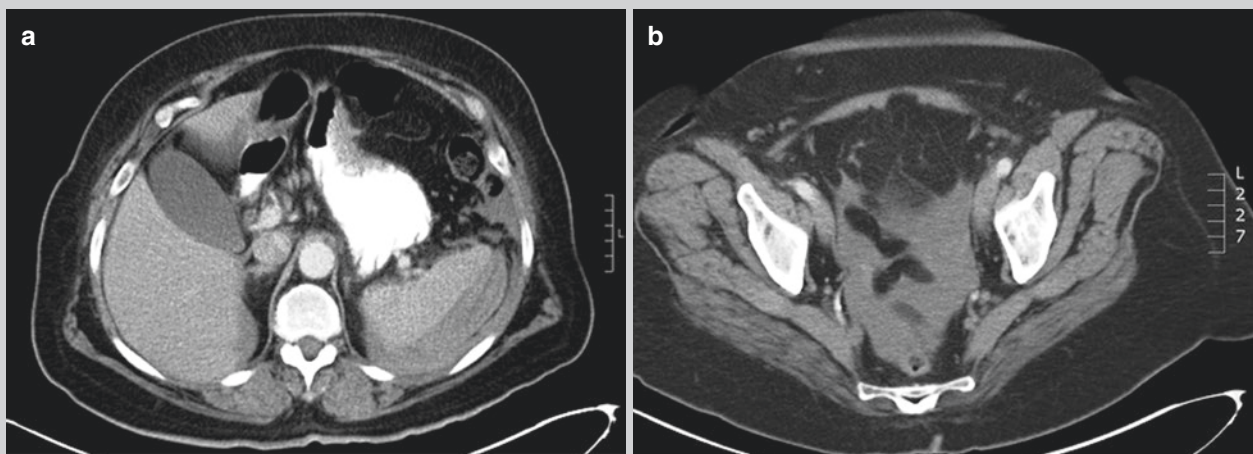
CT scan of the abdomen with intravenous contrast. (a) A 3 cm subcapsular hematoma with (b) associated large hemoperitoneum
